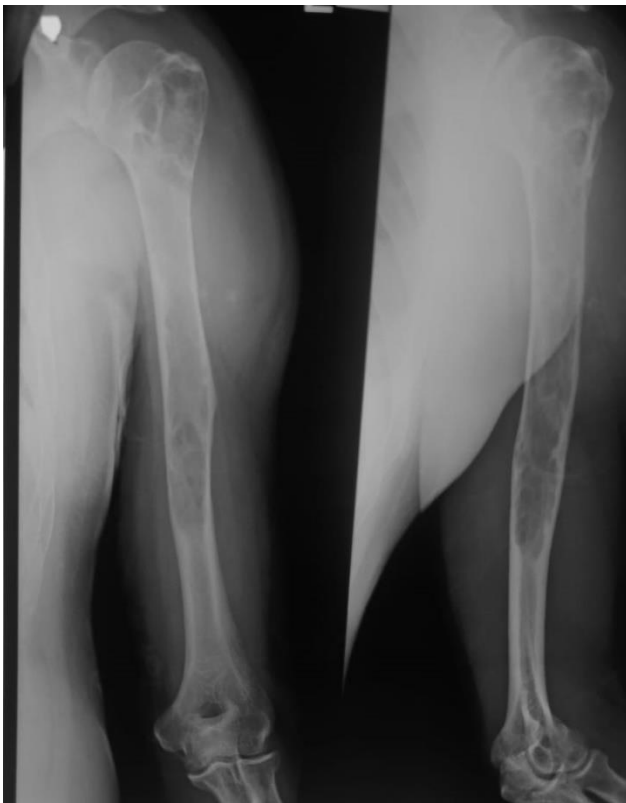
Plain radiograph of the left humerus: At the time of presentation the patient had complaint of left upper arm pain, on radiological evaluation it was found to have osteolytic lesions with cortical thinning involving more than half of the humerus.
